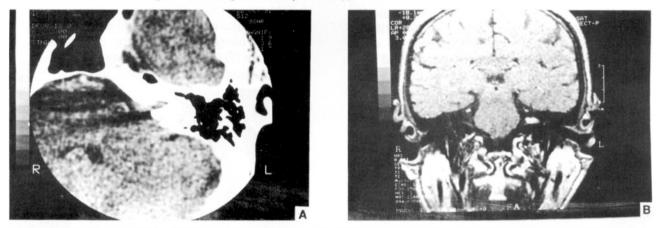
A.B: (Case 3) Magnified soft tissue CT image of left temporal bone showing a contrast-enhanced intracanalicular acoustic neuroma with intact IAC walls (A). Contrast-enhanced coronal short TRshort TE MR image of the same patient confirming the diagnosis of intracanalicular acoustic neuroma on the left side (B).
